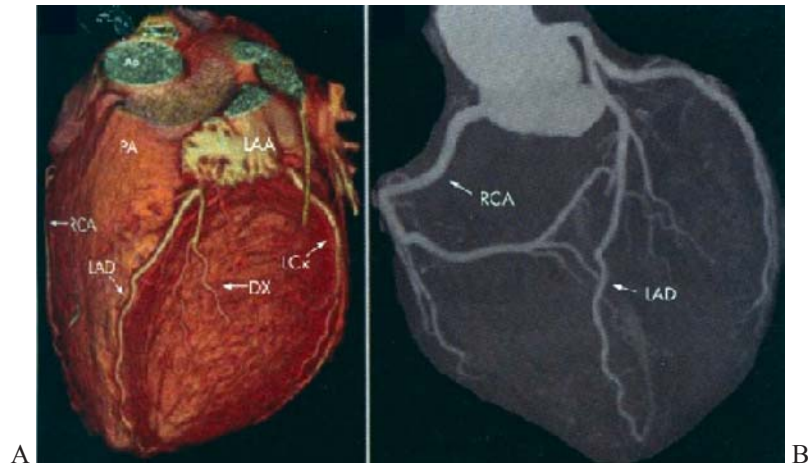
CT Angiography showing normal Coronary Arteries
